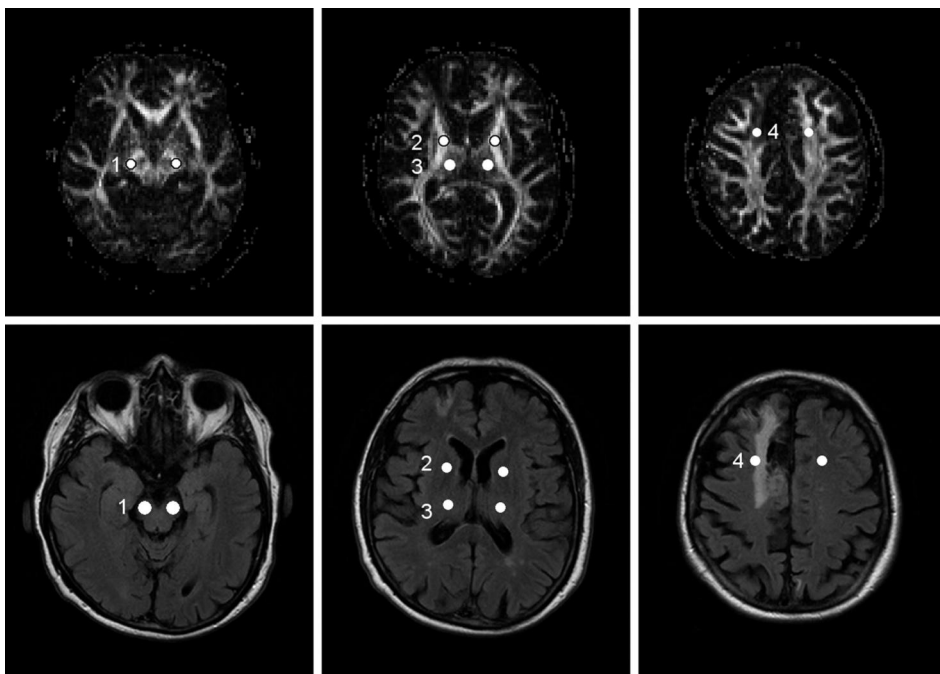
DTI (upper row) and MRI image levels and ROIs in cerebral peduncle (1), thalamus (2), internal capsule (3), and centrum semiovale (4).
